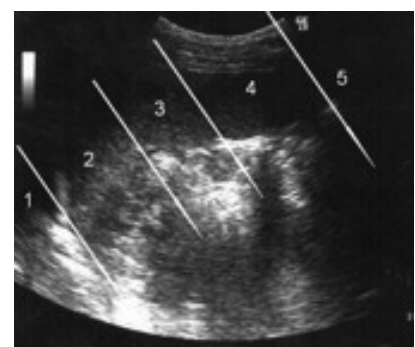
Longitudinal sonogram. Demonstrating of drainage vessels of accessory spleens.
